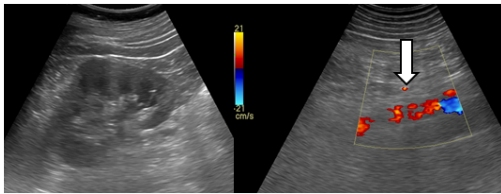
Ureteral stone without twinkling artifact. Color Doppler application of the kidney without the presence of hydronephrosis: a middle ureteral stone without a posterior twinkling artifact (fat arrow)
